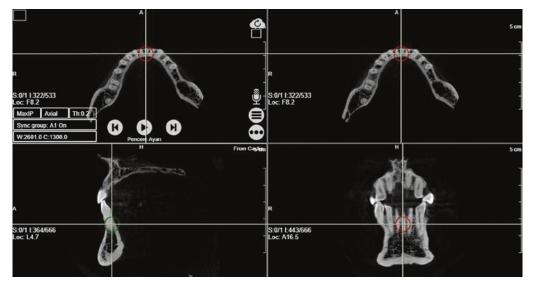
It is possible to view the region evaluated in three different plans with CBCT
